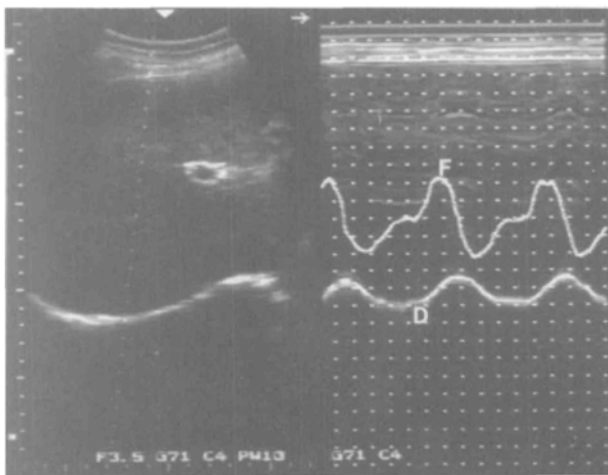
Diaphragm sonograms in a normal subject breathing through the mouth piece. A, B-mode sonogram (left) showing the diaphragm as a bright echoic line, and the M-mode marker as a dotted line; M-mode sonogram (right) showing the diaphragm motion tracing (D) with the superimposed air flow tracing (F).
